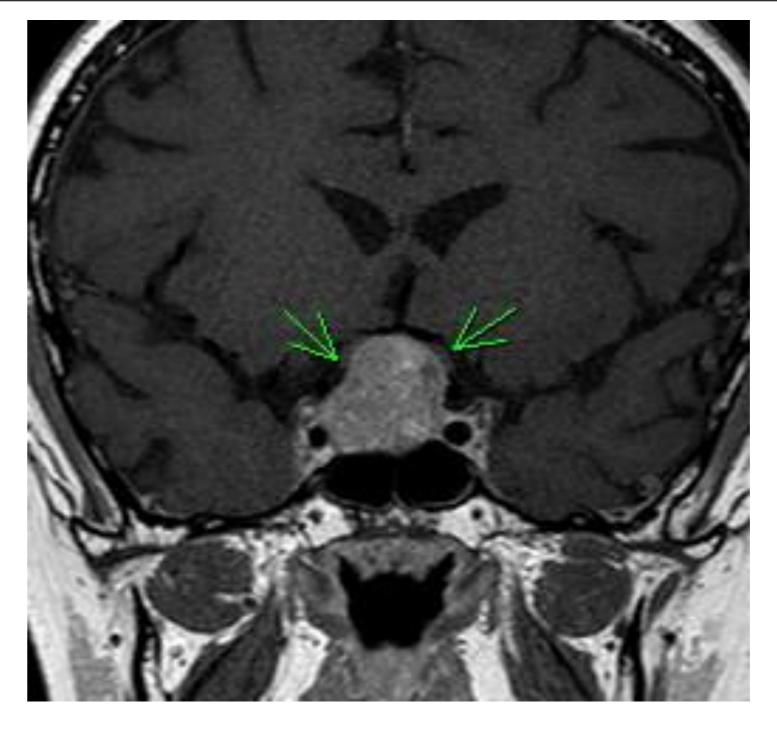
MRI brain at presentation T1 weighted enhanced by gadolinium. coronal and sagittal views showing a large pituitary macroadenoma(2.1x1.6x2.3 cms)
